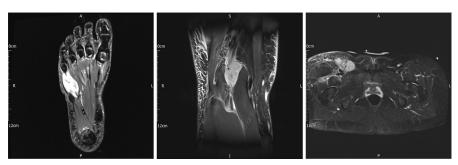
MRI scans of a 15-year girl with a fusion-positive RMS of the right foot and lymph node metastases in the popliteal fossa and groin.
